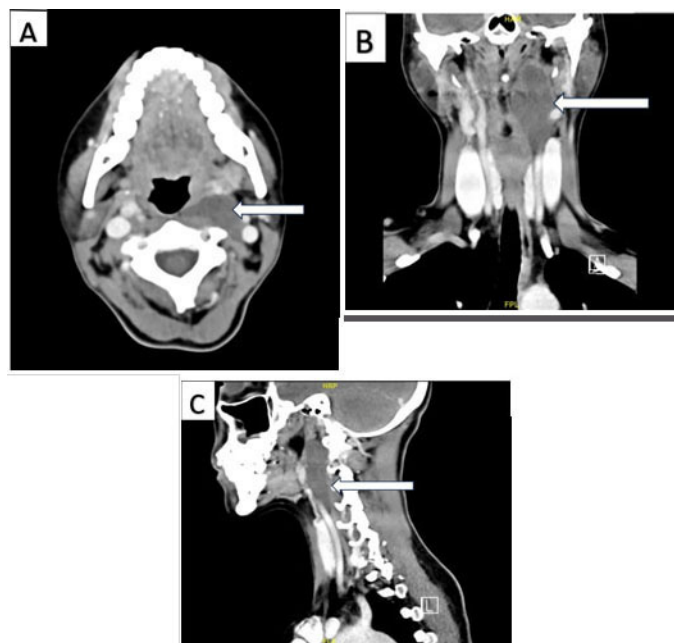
Contrast-enhanced CT scans of the neck. (A) Axial views, (B) Coronal views, and (C) Sagittal views of a contrast-enhanced CT neck show a hypoattenuating partly defined non-capsulated lesion (white arrows) at the left parapharyngeal space measuring 6.16×3.14×1.99 cm.
